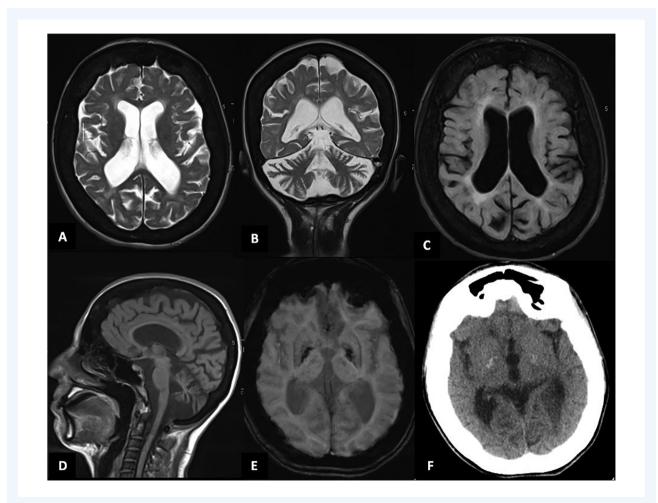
(A–D) Prominent thickening and sclerosis of calvarium, diffuse cerebral and cerebellar atrophy, periventricular non-specific T2 hyperintensities were seen at axial and coronal T2, axial FLAIR and sagittal T1 images. (E) SWI shows bilateral paramagnetic matter deposition at globus pallida. (F) Bilateral calcifications at globus pallida, prominent thickening and sclerosis of calvarium on CT imaging are seen.
